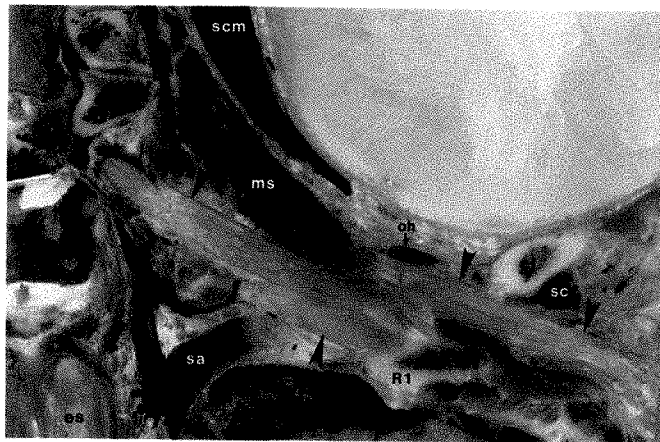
Coronal sections and MR images of left supraclavicular fossa. See key for abbreviations.
